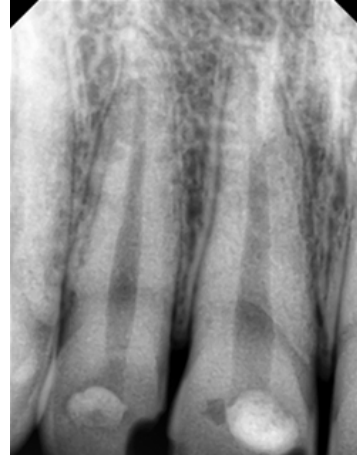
Periapical radiograph of the fractured teeth revealed normal periapical tissues with healthy periodontal structure.
